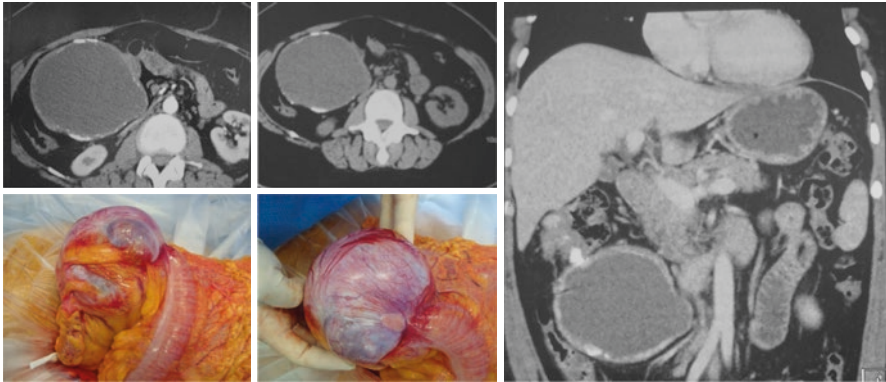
A 45-year-old female patient complaining of mass in the right hypochondrium, with noticeable mobility on physical examination. A cystic lesion with peripheral calcifications is observed on CT. Colonoscopy demonstrated signs of extrinsic compression and irregularity in the mucosa of the proximal transverse colon. Note the intraoperative finding of primary solid-cystic mass of the transverse colon wall. Segmental colectomy with regional lymphadenectomy was performed. Definitive diagnosis of high-grade sarcoma with epithelioid component and ossification, primary of the transverse colon
